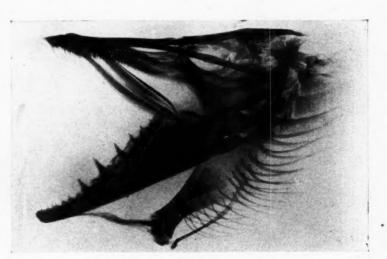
Radiograph of jaws of pickerel.
